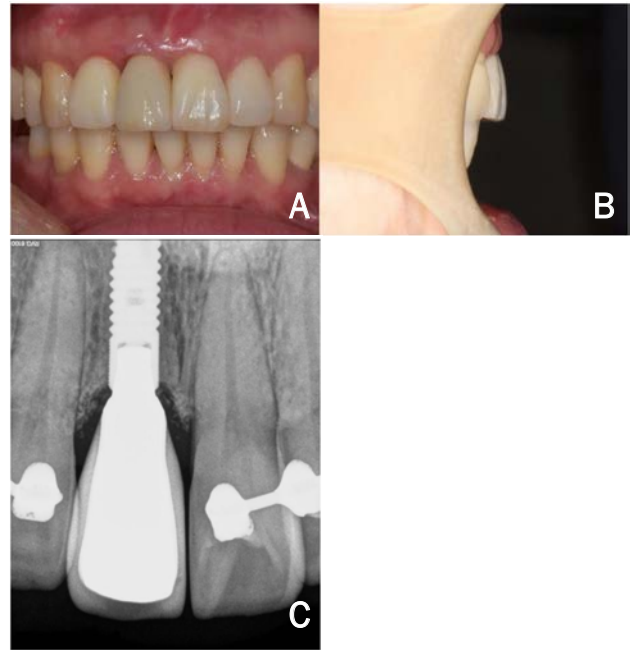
Post-operative photographs. (A) Frontal view. (B) Lateral view. (C) Periapical radiograph.
